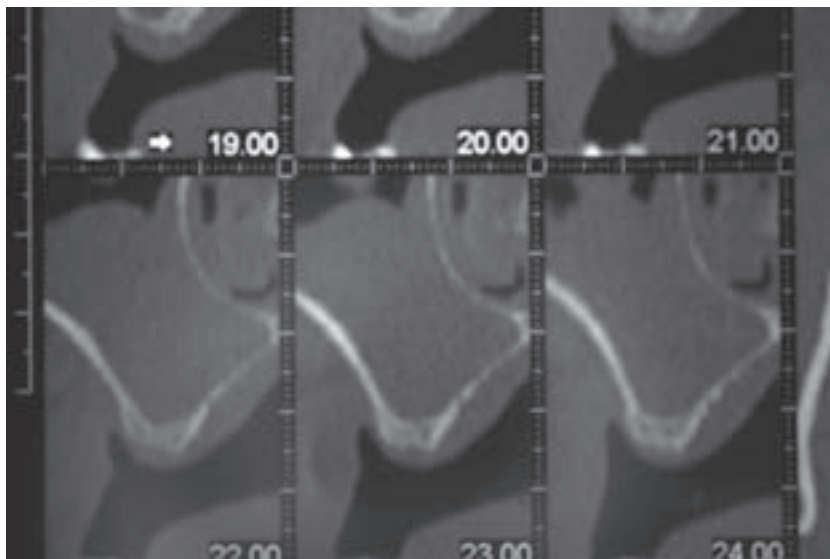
CT scan after extraction of the molars.
